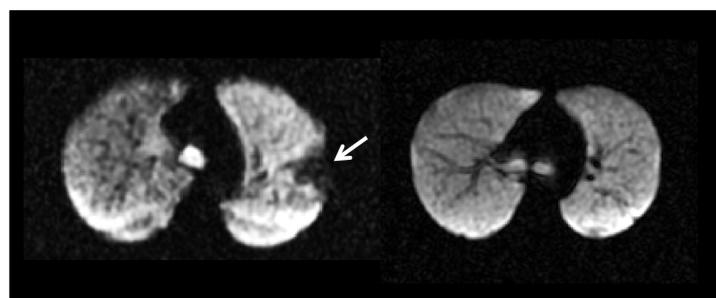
Example from HP-MRI of typical ventilation defect (left, arrow) compared to healthy lung (right).
